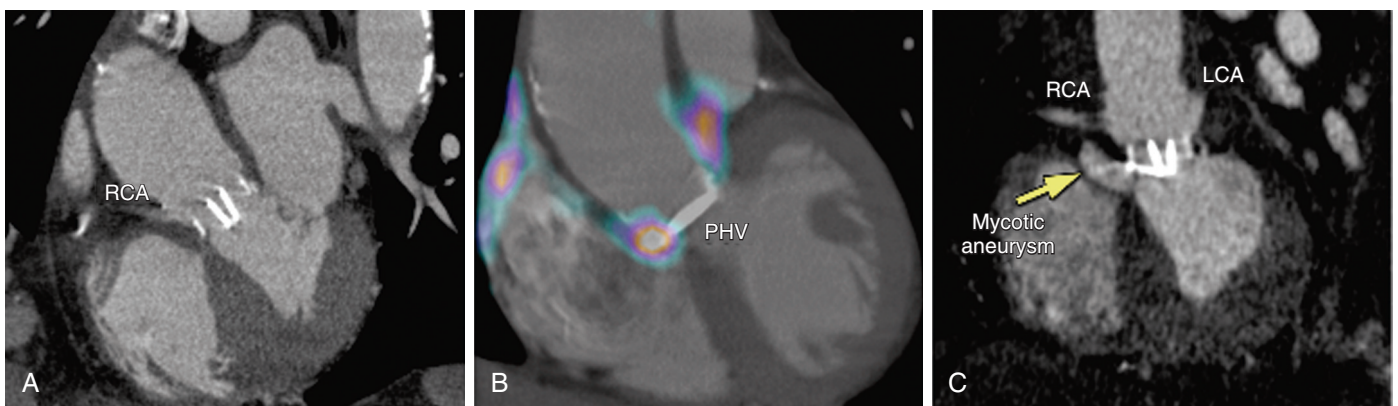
Periannular prosthetic valve endocarditis detected by FDG PET. A patient with a bileaflet mechanical prosthetic aortic heart valve (PHV), placed 20 years earlier, presented with fever and blood cultures positive for *S. aureus*. Despite a high degree of clinical suspicion for endocarditis, findings on transthoracic echocardiography and TEE, as well as CT (A), were unremarkable for evidence of infection. B, FDG PET-low-dose CT fused image revealed high uptake around the aortic PHV (arrows), near the proximal right coronary artery (RCA). C, Subsequently, CT revealed a mycotic aneurysm beneath the RCA origin, confirmed by urgent operation. In this case, only FDG PET-CT detected these abnormalities at a very early stage. LCA = left coronary artery. (A, B, Modified from Tanis W, Scholtens A, Habets J, et al: Fusion of cardiac computed tomography angiography and ¹⁸F-fluorodesoxyglucose positron emission tomography for the detection of prosthetic heart valve endocarditis. *J Am Coll Cardiol Img* 6:1008, 2013.)
